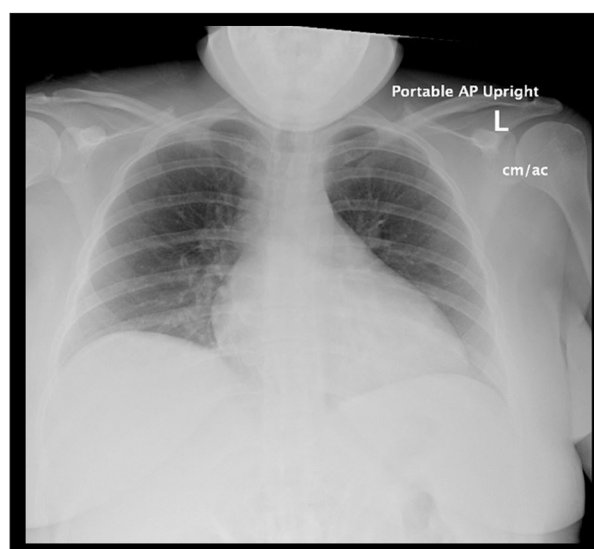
Portable chest x-ray did not show any infiltrate.
